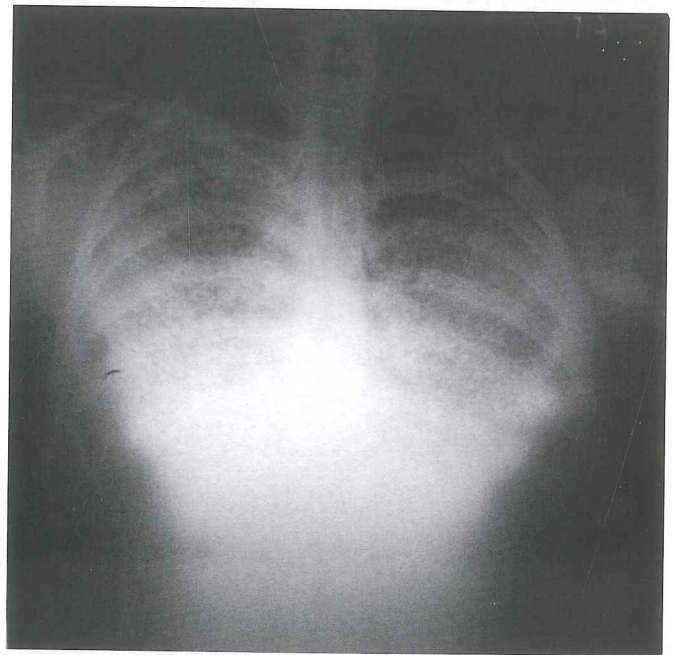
Chest x-ray of index patient with PAM. Note the predominantly perihilar infiltration of fine dense nodules that obliterate the cardiac and medial diaphragmatic borders.
